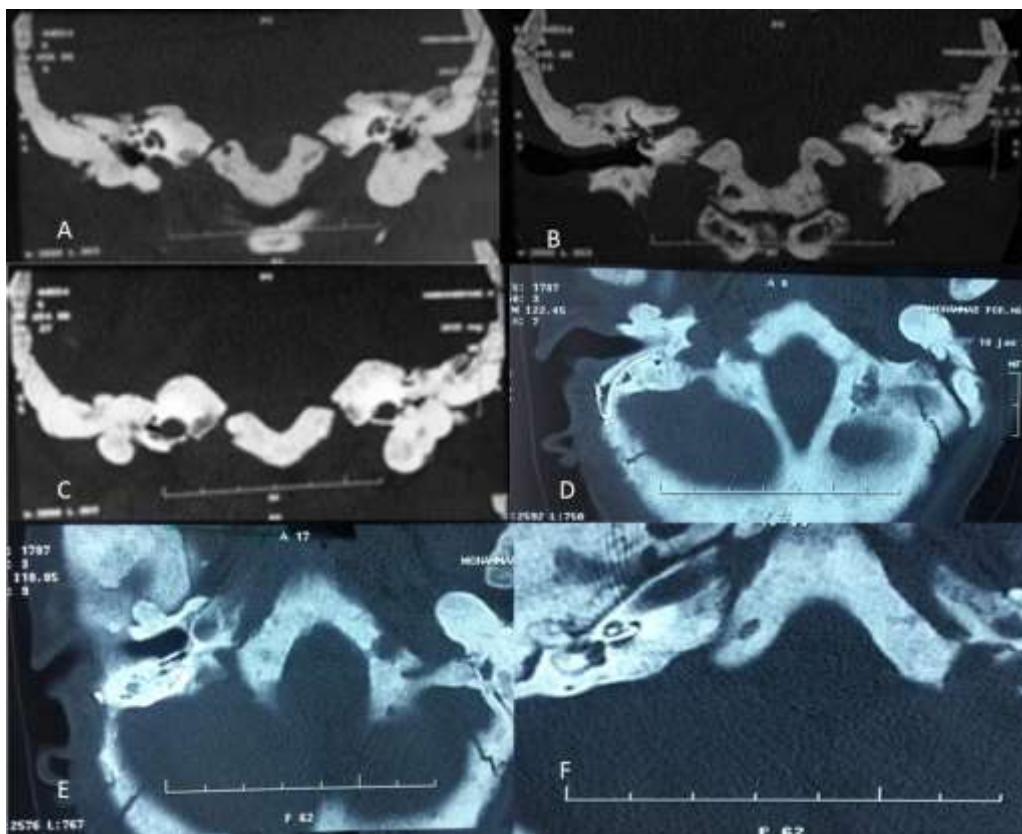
The sections of skull CT scan images before (A, B, C) and after cochlear implantation (D, E, F).
